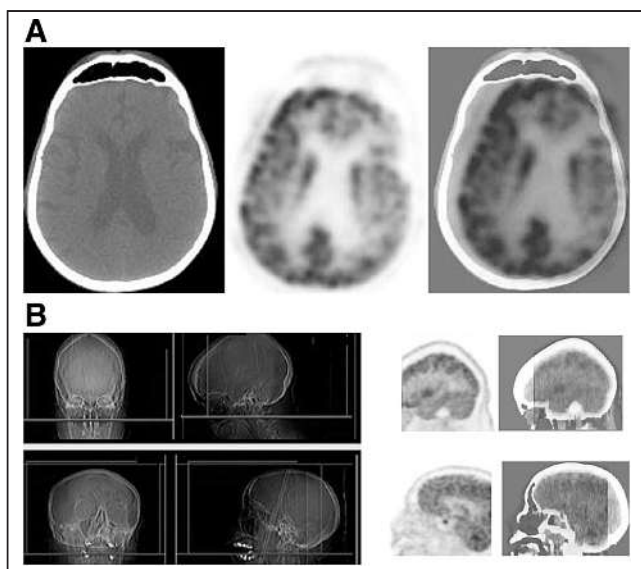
(A) Brain ^{18}F -FDG PET/CT images with technologist-caused motion artifact due to misplacing of region-of-interest box on scout images. (B) Transaxial and sagittal lateral radiographs (left), PET images (middle), and PET/CT images (right) of head. Artifact causes false reduction in uptake in left hemicortex and results in part of brain being cut off in final images (12).
